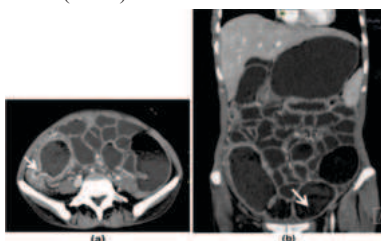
Ileocaecal tuberculosis. (a) Axial CT image shows gaping ileocaecal valve with mural thickening in this region (arrow). (b) Coronal CT image shows markedly dilated distal ileum with presence of small bowel faeces sign (arrow). Small bowel faeces sign is a CT sign seen in small bowel obstruction because of the intermixing of air with material that is static in obstructed small bowel proximal to transition zone
